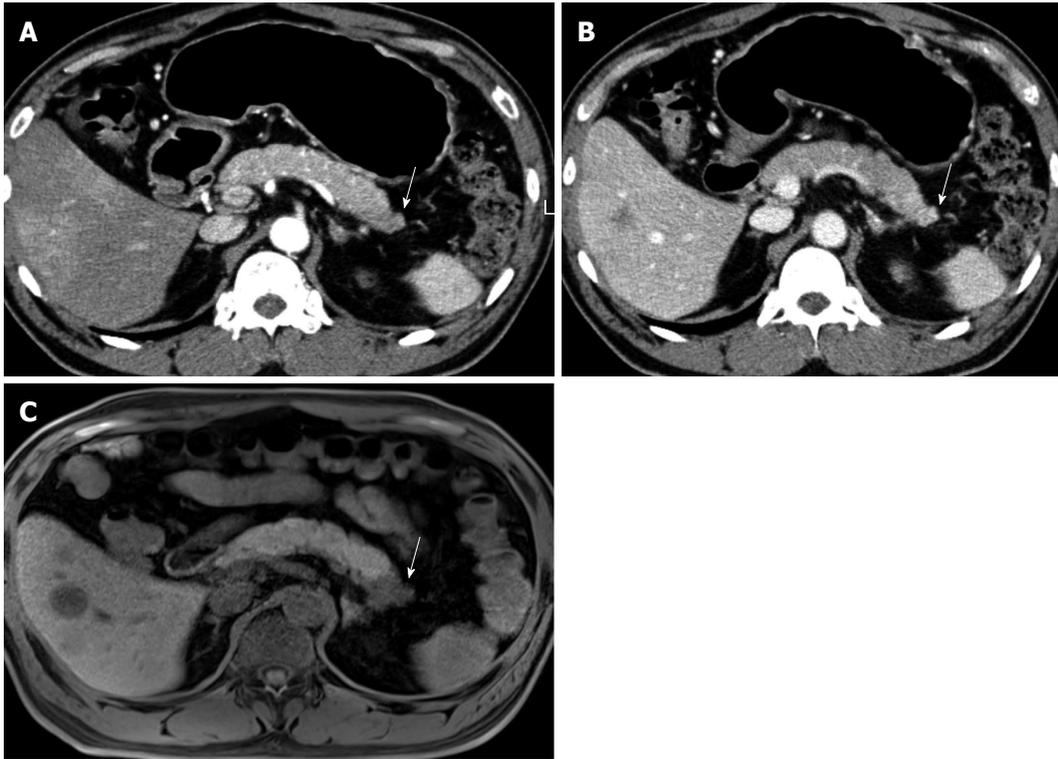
A 64-year-old male with biopsy-proven pancreatic adenocarcinoma with liver metastasis. A, B: On MDCT, the pancreatic tail mass (arrow) shows iso-attenuation, causing distal parenchyma atrophy; C: On pre-contrast, T1-weighted, gradient-echo sequence MRI, the pancreatic tail mass (arrow) is clearly depicted, as well as the liver metastasis, owing to the increased soft-tissue contrast of MR compared with that of CT. MRI: Magnetic resonance imaging; MDCT: Multi-detector computed tomography.
